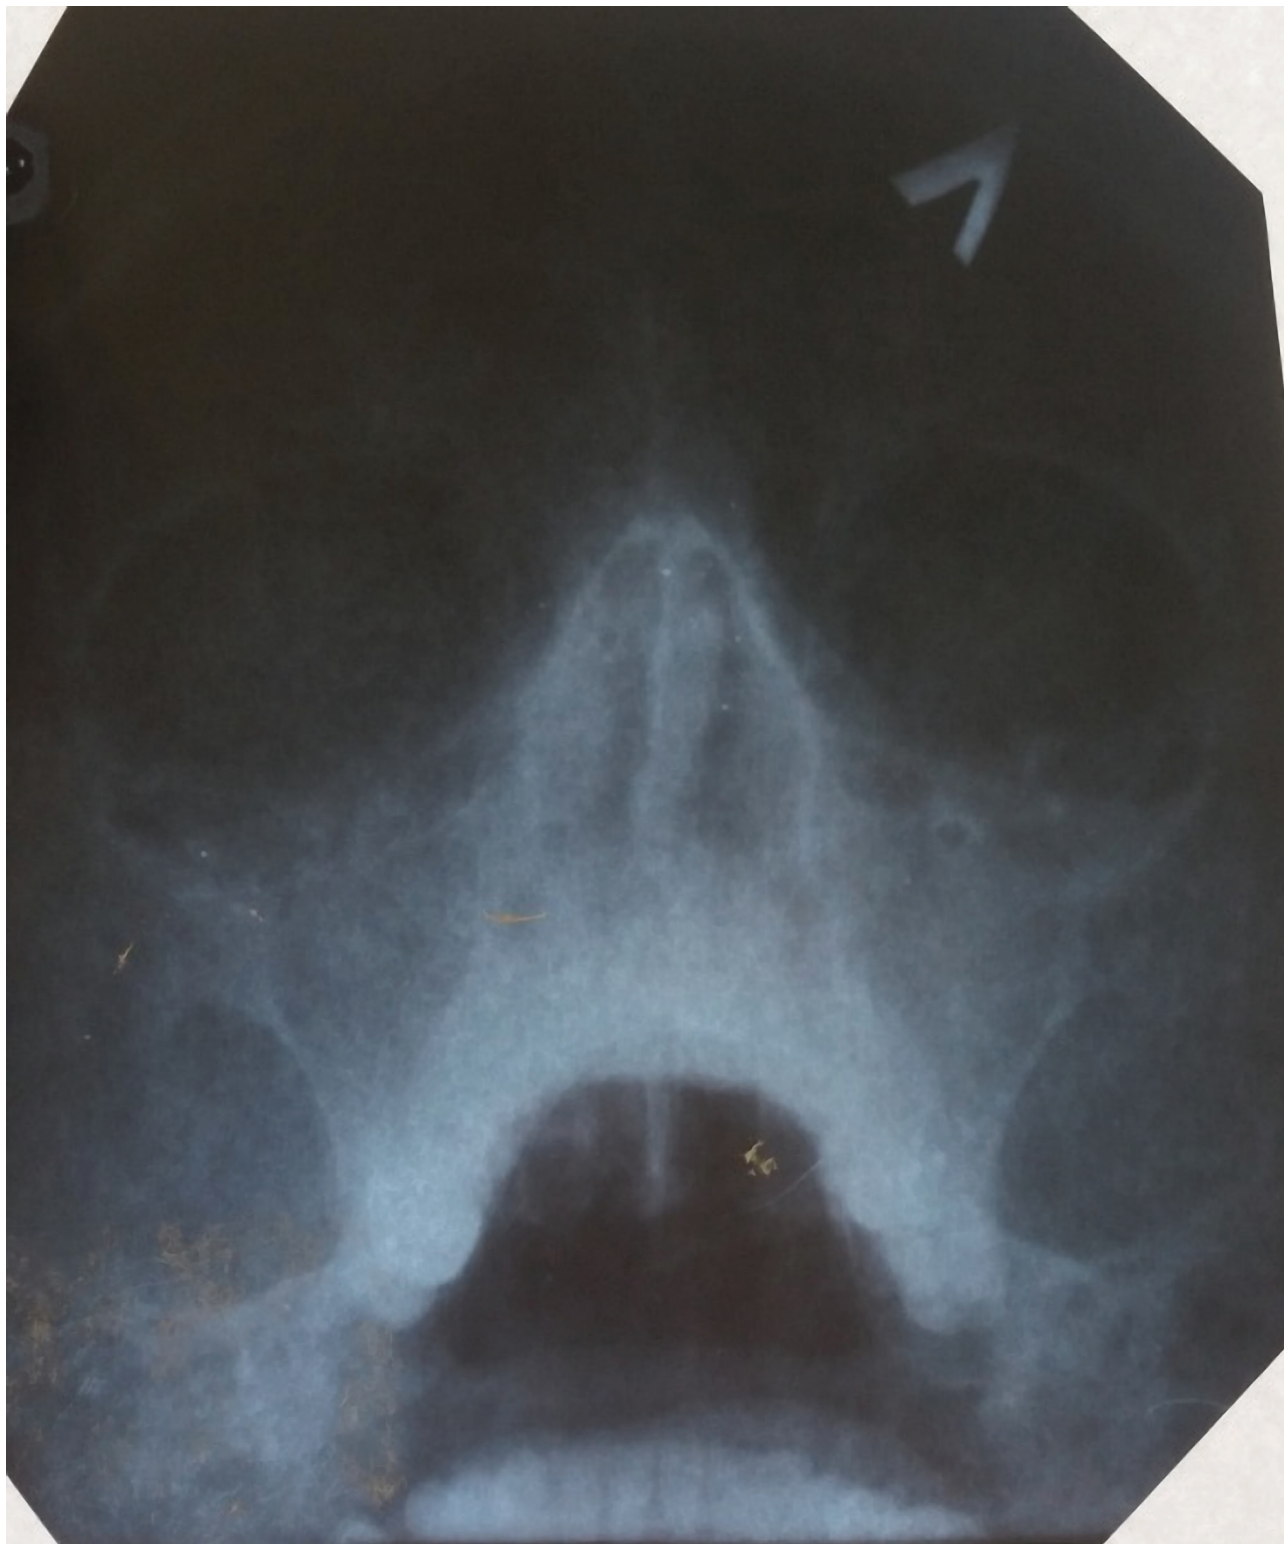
X-ray of the paranasal sinuses in patients with chronic purulent maxillary sinusitis with type 1 diabetes mellitus.
